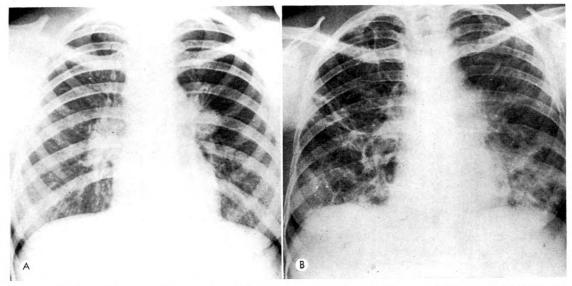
(A) Roentgenogram of a 25 year old Negro woman with Boeck's sarcoid. The mediastinal lymph nodes are enlarged. The lungs appear well ventilated. (B) Roentgenogram of the same patient 4 years later. Note that extensive fibrosis of the interstitial tissues of the lungs has resulted in very irregular ventilation. In addition, one can anticipate a decreased volume of air in the lungs and difficulty in moving air in and out because of the increased fibrous tissue, which is not elastic. The patient died later of pulmonary failure.
